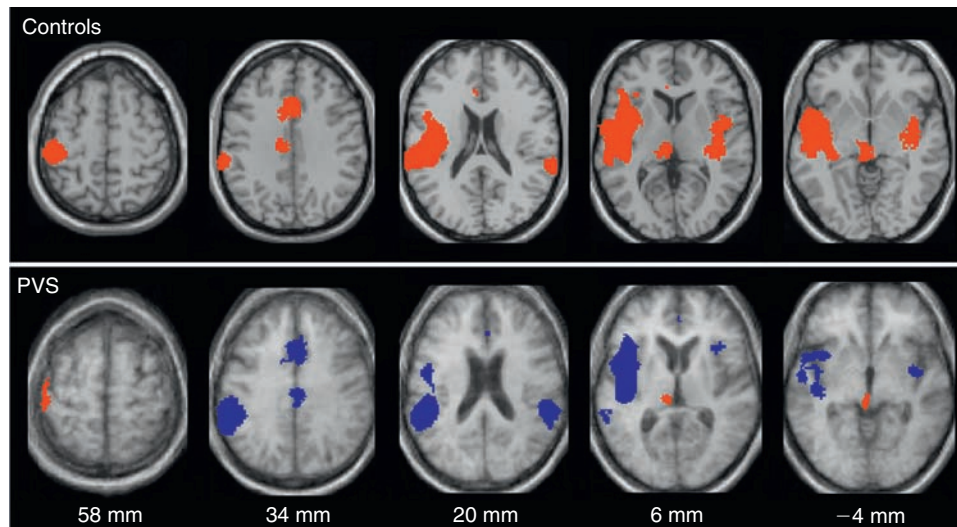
(Upper) Brain regions, shown in red, that activated during noxious stimulation in controls (subtraction stimulation–rest). (Lower) Brain regions that activated during stimulation in vegetative state patients, shown in red (subtraction stimulation–rest) and regions that activated less in patients than in controls (interaction (stimulation vs. rest) \times (patient vs. control)), shown in blue. Projected on transverse sections of a normalized brain MRI template in controls and on the mean MRI of the patients (distances are relative to the bicommissural plane). *Source:* Adapted from Laureys *et al.* [32].
